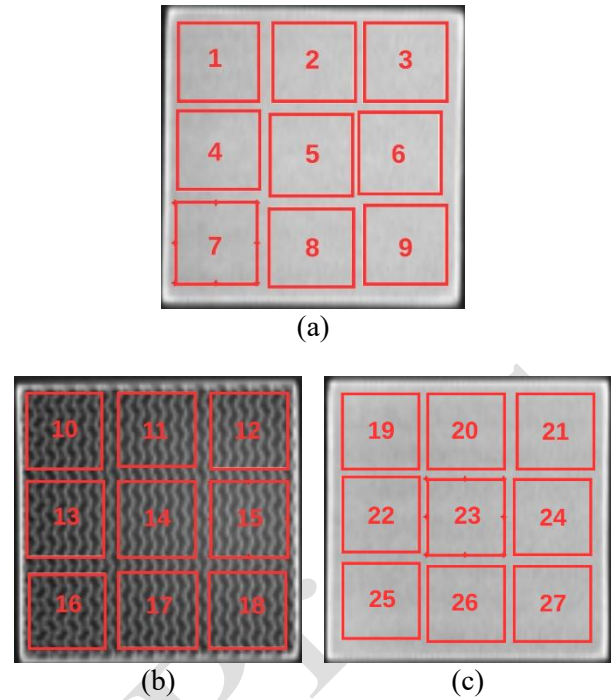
CT number measurement at the (a) top layer, (b) infill layer, and (c) bottom layer.
